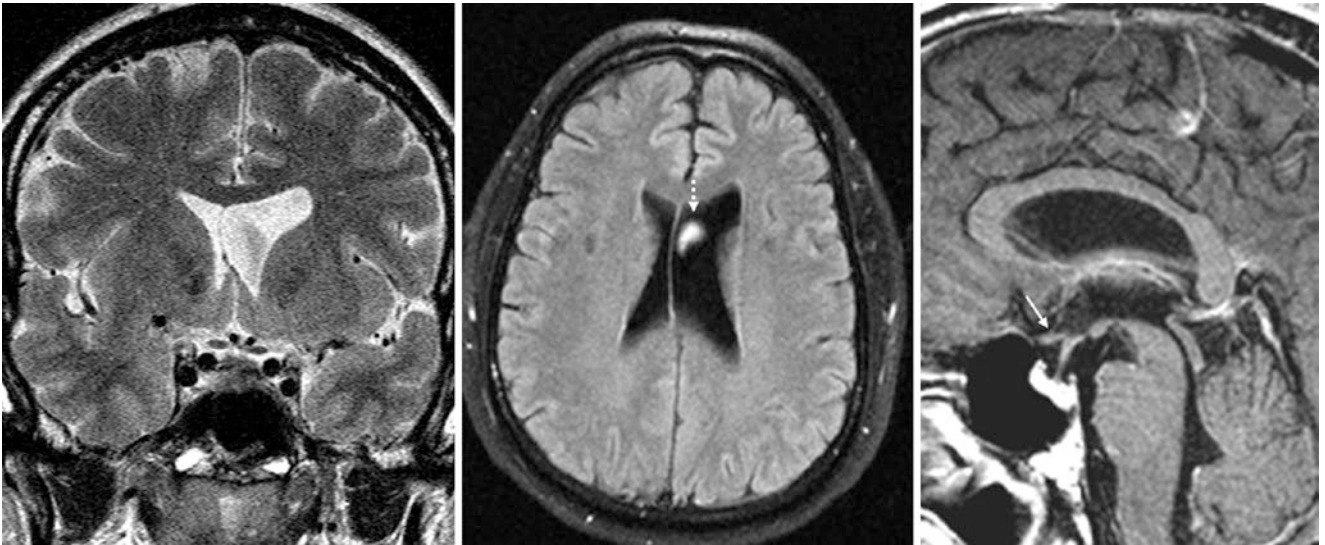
A 55-year-old patient in whom coronal T2WI (*left*) and axial FLAIR (*middle*) images showed asymmetric enlargement of the left lateral ventricular body. On sagittal T1WI (*right*), the third ventricle's
